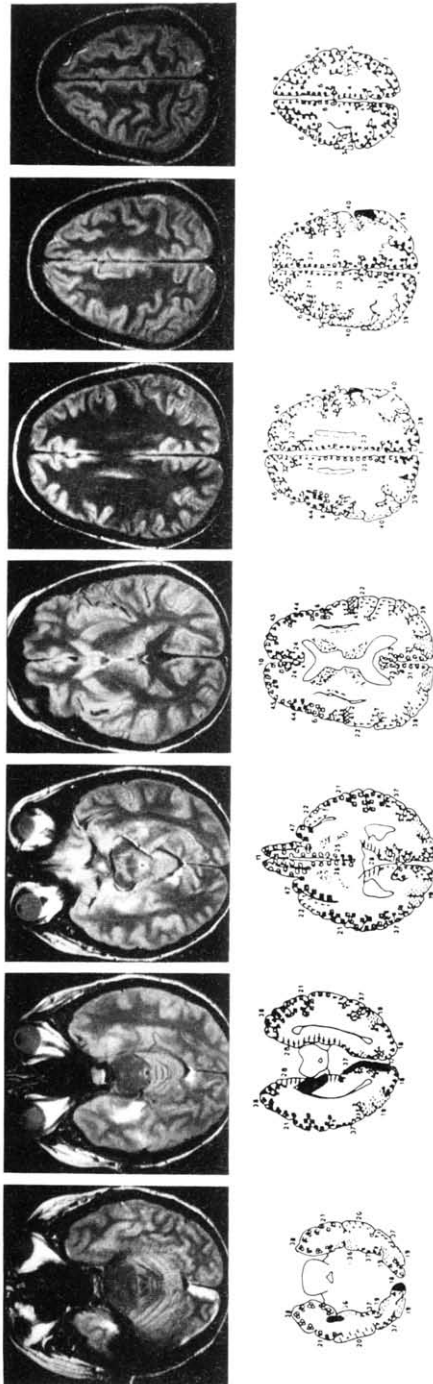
MRI and anatomical templates in the top row show the proton density weighted MRI transverse sections depicting two discrete areas of infarction. The relevant lesion is located in the left inferior parietal lobe, and involves part of Brodmann area 40 and to a lesser degree area 39. The second and larger area of infarction involves right mesial temporal, retrosplenial, and mesial occipital cortices.
